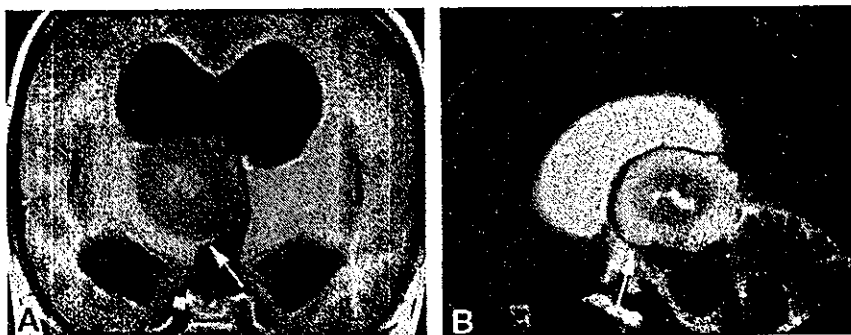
A, Coronal image after administration of gadolinium-DTPA (500/20 [TR/TE]). B, Sagittal T2-weighted image (4000/88.9 [TR/TE]). The margin of the mass lesion is covered with thalamus extending in a beaklike shape (arrows).
